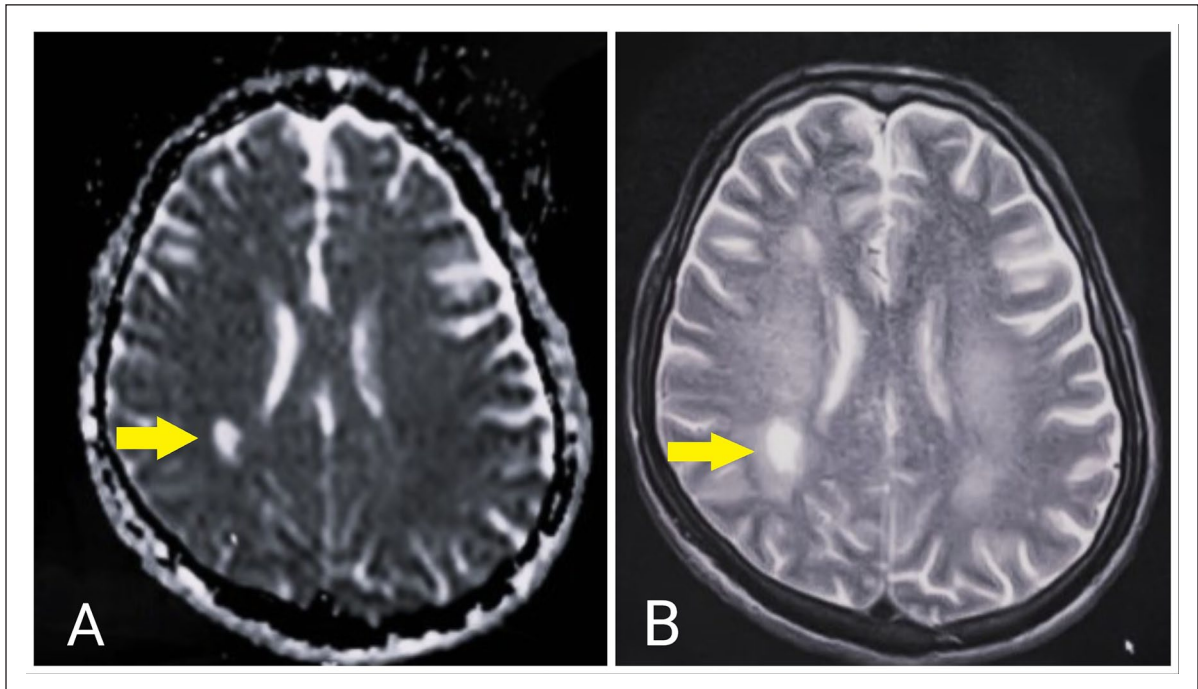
An MRI of the brain; (A) without contrast and (B) with contrast. A non-enhancing, fluid signal intensity area in the white matter of the Right Parietal lobe shows peripheral high signal and restriction (yellow arrow).
